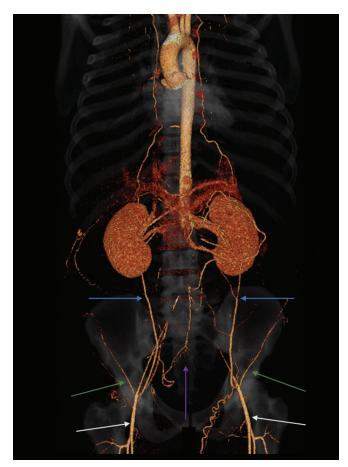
Coronal computed tomography angiogram, maximum intensity projection, of a 22-year-old man with systemic lupus erythematosus and secondary antiphospholipid syndrome, showing complete occlusion of the infrarenal abdominal aorta and common iliac arteries, with reconstitution of bilateral femoral arterial perfusion via numerous collaterals, including the inferior epigastric, intercostal, superior mesenteric and inferior mesenteric artery branches. Blue arrows indicate inferior epigastric artery collaterals, purple arrow indicates superior rectal artery collaterals, green arrows indicate deep circumflex arteries (with collateralization via intercostal arteries, not shown) and white arrows indicate reconstituted flow in the femoral arteries via proximal collaterals.
